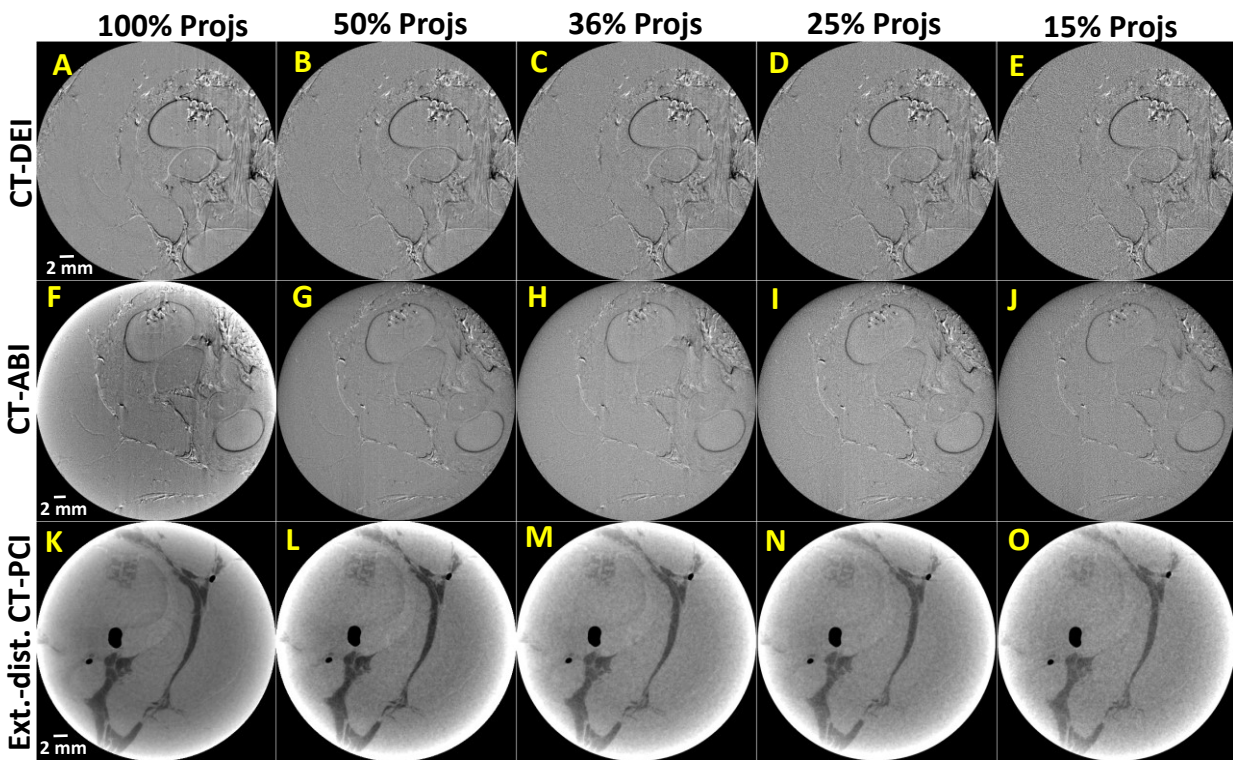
Region of interest (ROI) and CT imaging at reduced number of projections: (A-E) CT-DEI, (F-J) CT-ABI, and (K-O) extended-distance (ext.-dist) CT-PCI at (A, F, K) 100%, (B, G, L) 50%, (C, H, M) 36%, (D, I, N) 25%, and (E, J, O) 15% of the standard number.
